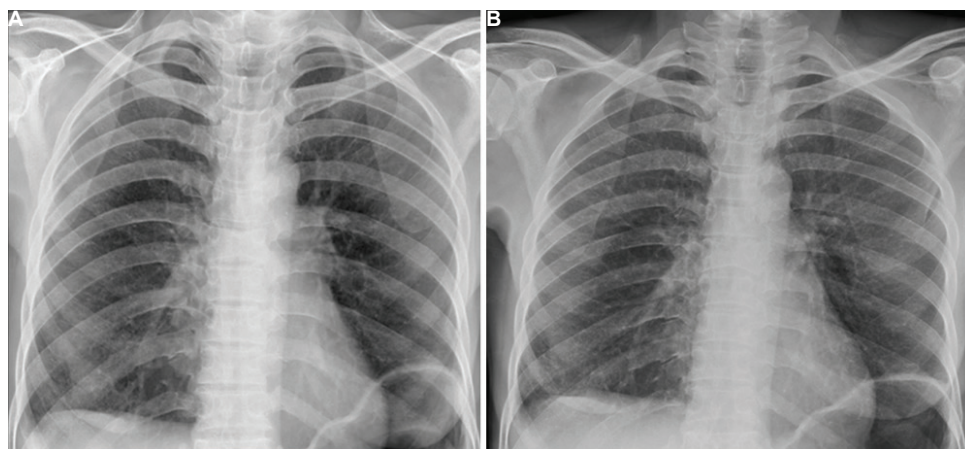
Chest X-ray images for the same individual without evidence of disease using (A) mine 2 machine, and (B) digital X-ray machine.
